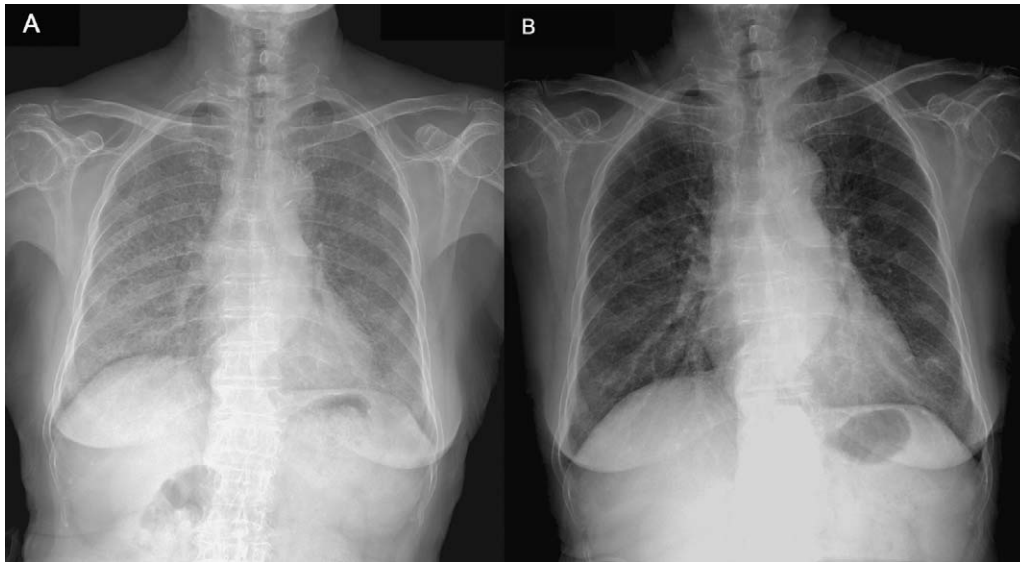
The initial chest X-ray showed bilateral diffuse interstitial infiltration and alveolar opacities (A), which resolved after the successful treatment of rhinocerebral aspergillosis (B).
